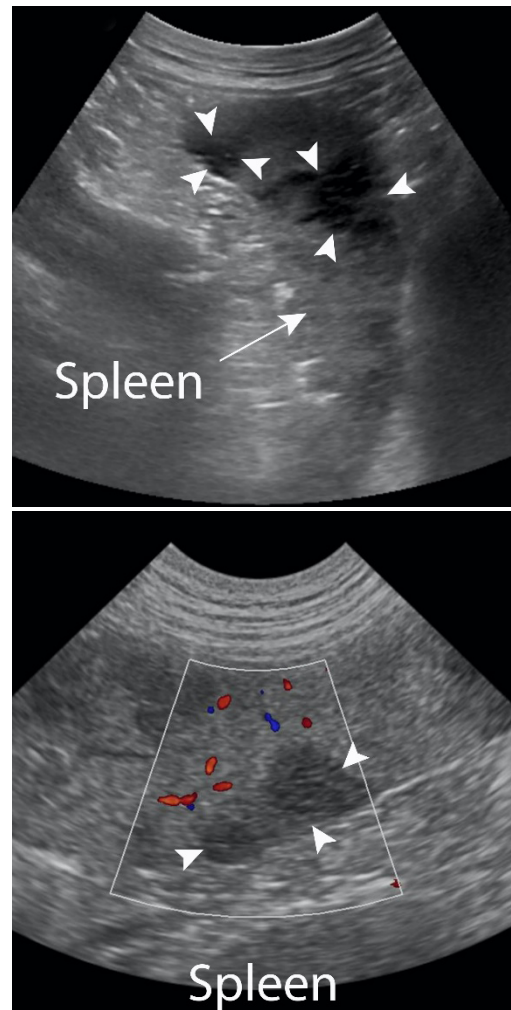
Longitudinal/crosssectional images of spleen. A. severely mottled spleen with innumerable hypoechoic regions (arrowheads) suggestive of acute, multifocal splenic infarcts. B. Decreased blood flow on Doppler.
